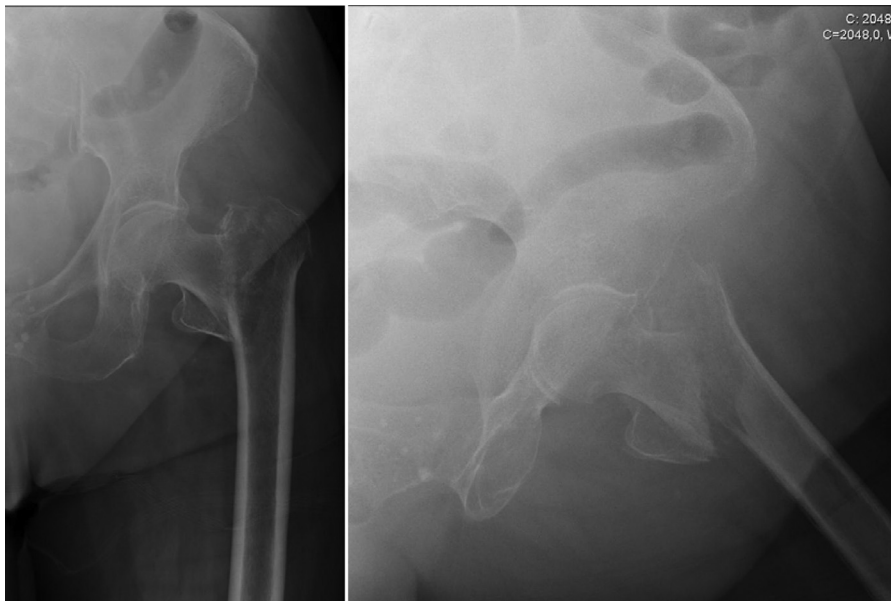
Radiograph disclosing an intertrochanteric fracture.
